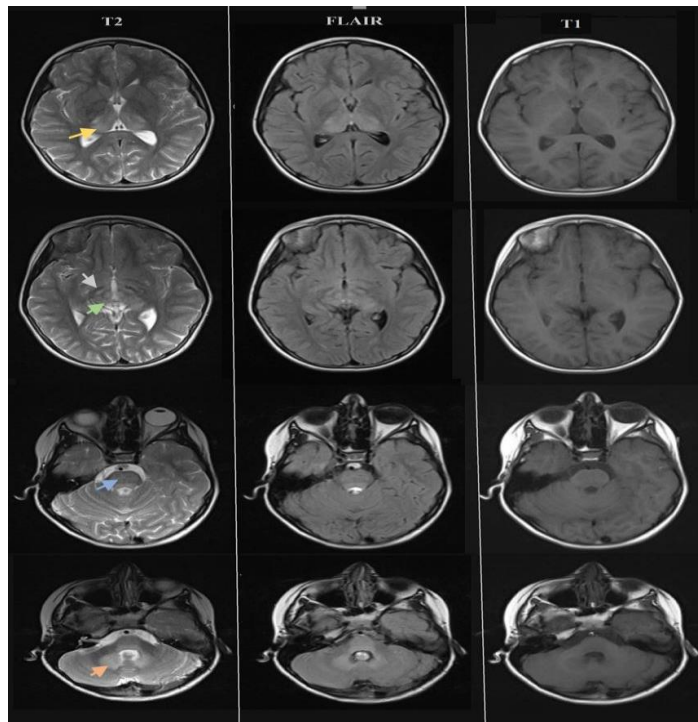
The Brain MRI of the Patient at the Age of 10 Years. Axial T2 Weighted and Flair Images Reveal Symmetrical Hyper Intensity of Thalami (yellow arrow), Globi Pallidi (White Arrow), Periventricular Matter of Third Ventricle and Subthalamic Nuclei and Pulvinar, With Sparing of the Mamillary Bodies, Phornics, Internal Capsule, and Putamen. The Signal Abnormality Extends to the Midbrain (Green Arrow), Pons (Blue Arrow), Medulla (Black Arrow), and Upper Segment of the Cord, With Involvement of Red Nucleus and Substantia Nigra and Periaqueductal Grey Matter and Tegmental Tract and Dentate Nucleus (Orange Arrow) with Sparing of Most of the Corticospinal Tract and Middle Cerebellar Peduncle
